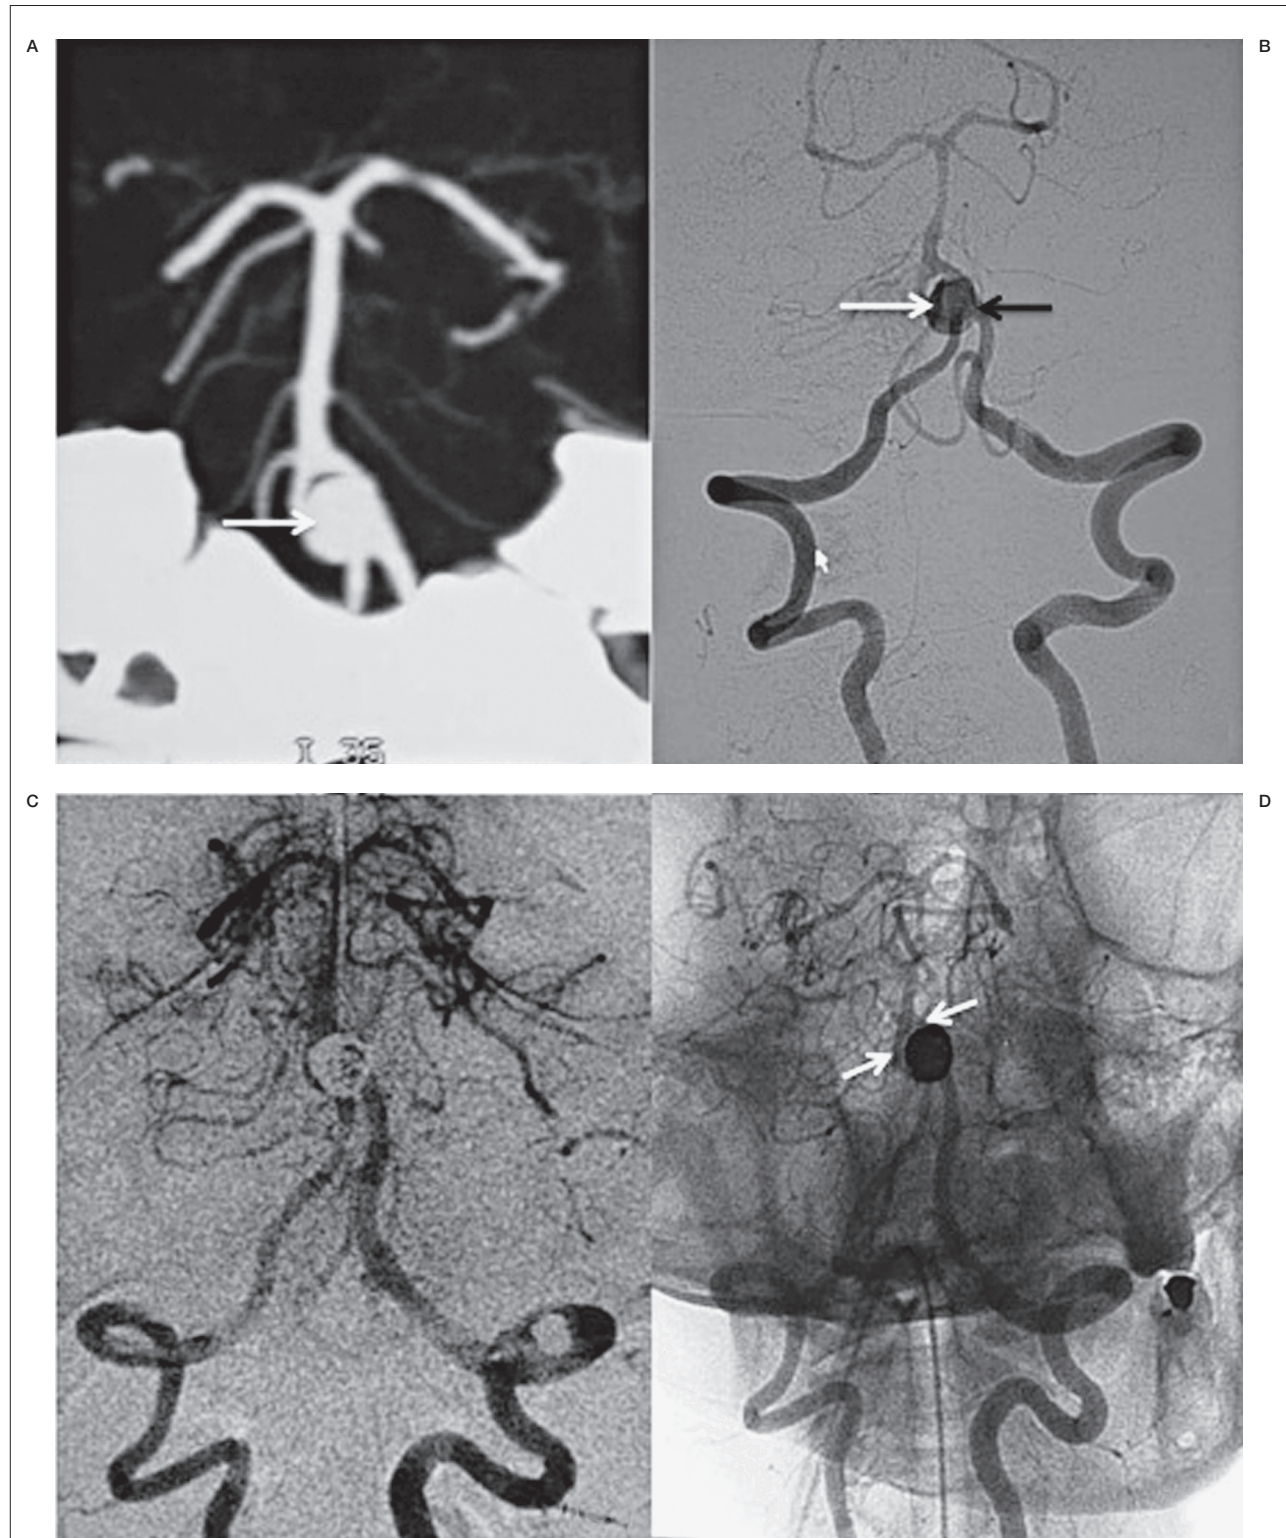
A) Pre procedure CT angiography. B) Digital subtraction angiography. C) Post procedure digital subtraction angiography. D) Post procedure unsubtracted angiography (D). A saccular aneurysm can be seen arising from the proximal bifurcation of the fenestration (white arrow in A and B) with incorporation of the left limb of the fenestration (black arrow in B). Post procedure images (C,D) show complete obliteration with the platinum coils with preservation of both limbs of the fenestration (arrows in D).
